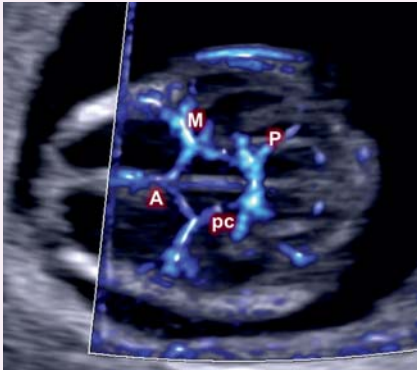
Axial view of normal fetal brain showing circle of Willis using highly sensitive Doppler imaging (MV flow) at 11–13 weeks. A, anterior cerebral artery; M, middle cerebral artery; P, posterior cerebral artery; pc, posterior communicating artery.
